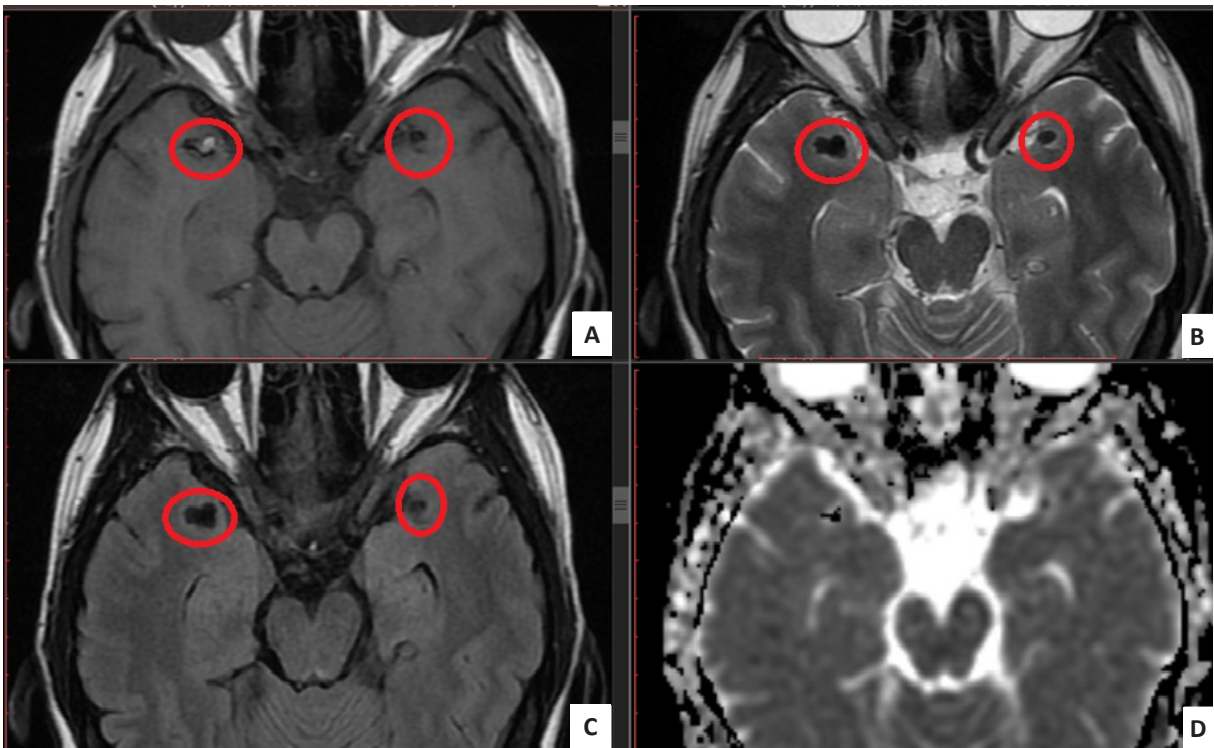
Preoperative magnetic resonance images (MRI) revealed bilateral middle cerebral artery aneurysms. The red cycles indicate the aneurysms; [A]: T1-weighted MRI; [B]: T2-weighted MRI; [C]: T2-flair-weighted MRI, [D]: Apparent diffusion coefficient (ADC).
